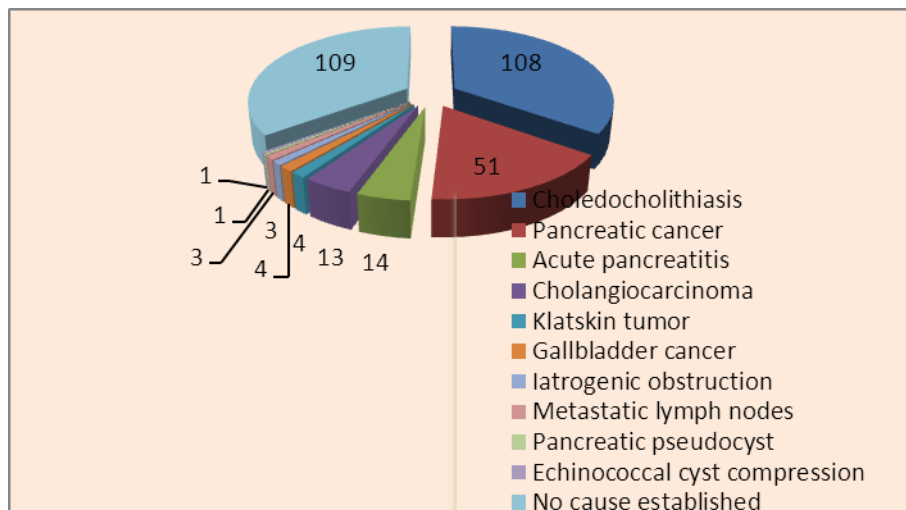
№9 Causes of extrahepatic cholestasis proved by ultrasound (n = 311)
